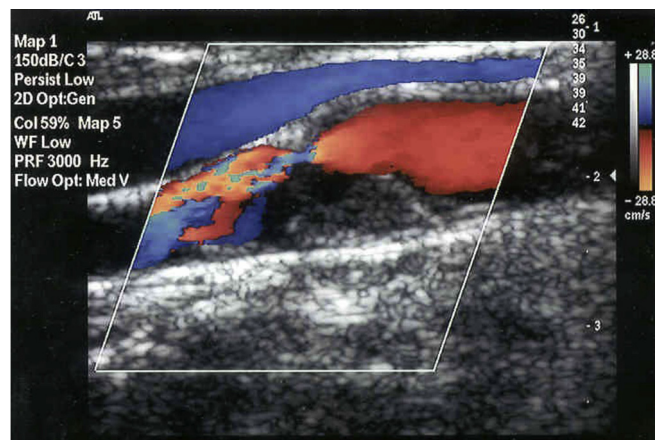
Duplex ultrasound image showing a severe stenosis within the ICA (arrow). The degree of stenosis is determined by morphological measurements and/or by assessment of increases in peak systolic or end-diastolic velocities across the area of narrowing.
